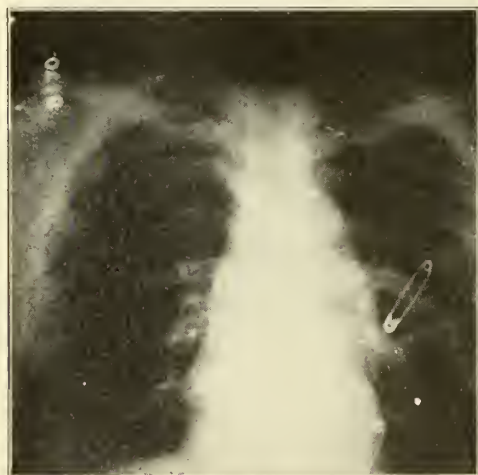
X-Ray 51702—Three months after operation Jan. 18, 1925
